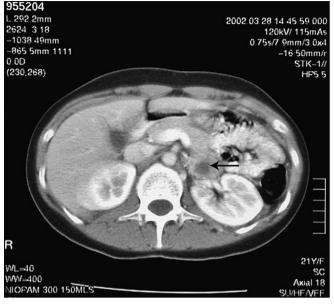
CT of the abdomen showing a left-sided adrenal mass.
